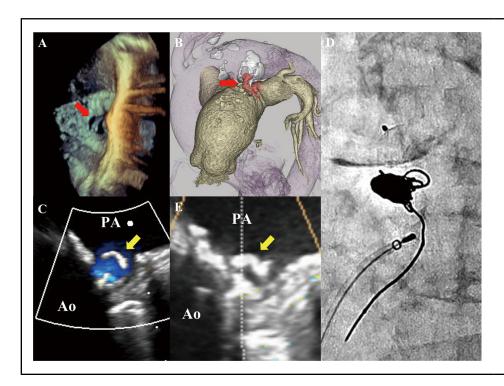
Patent ductus arteriosus (PDA) treatment. (A) The 2 PDA exit points on the pulmonary arterial side (red arrow) on transesophageal echocardiography (TEE). (B) PDA (red arrow) on computed tomography. (C) Residual shunt on TEE after plug (yellow arrow) implantation. (D) Microcoils in the plug technique. (E) No residual shunt on TEE after microcoils used with the plug (yellow arrow) technique. Ao, aorta; PA, pulmonary artery.
